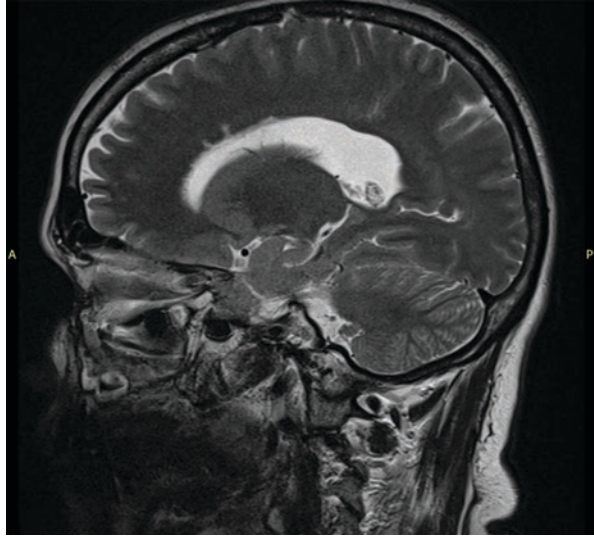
MR sagittal FLAIR image showing focal radially oriented hyperintense lesions in the periventricular region consistent with multiple sclerosis. Note the subtle presence of “Dawson fingers” emanating radially outward from the corpus callosum in a fimbriated pattern
